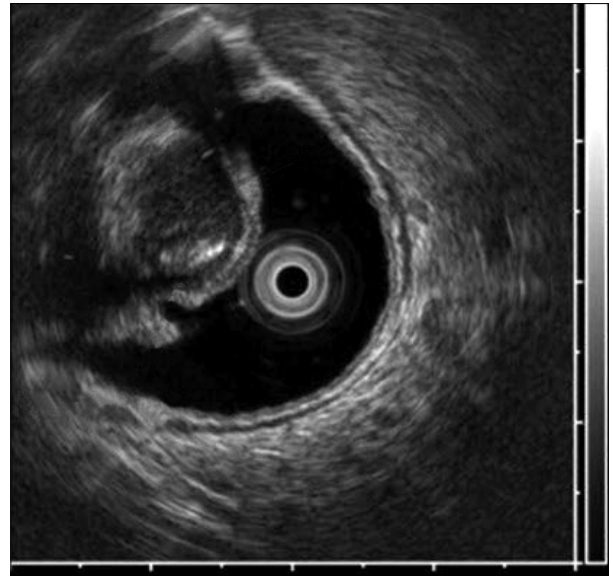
Endoscopic ultrasonography findings. The bulging stalk was cystic with a hypoechoic structure and small hyperechoic areas in the submucosa.
